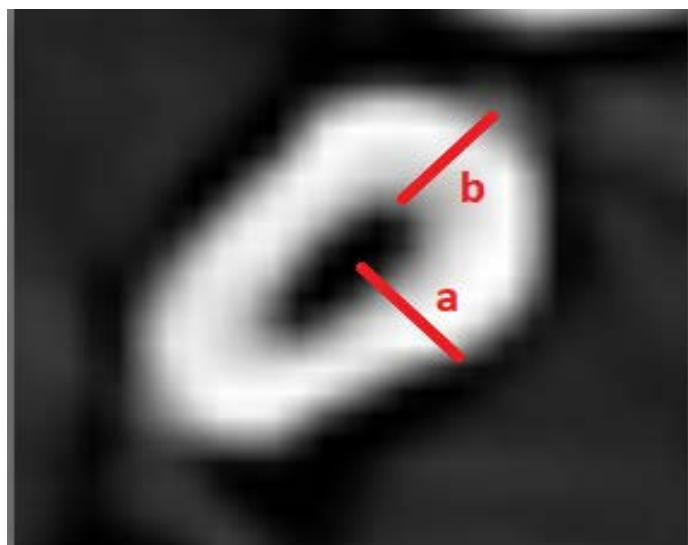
Determination of remaining dentin thickness of pre- and post-instrumentation cone-beam computed tomography images. a: Preinstrumentation b: Postinstrumentation.
